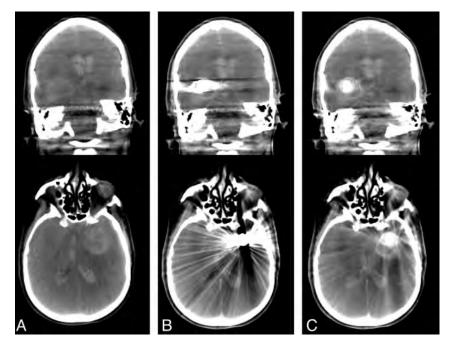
Coronal (*top row*) and axial sections (*bottom row*) of conebeam CT data of a patient acquired before coil embolization (*column A*), after coil embolization without MAR (*column B*), and after coil embolization with MAR (*column C*).
